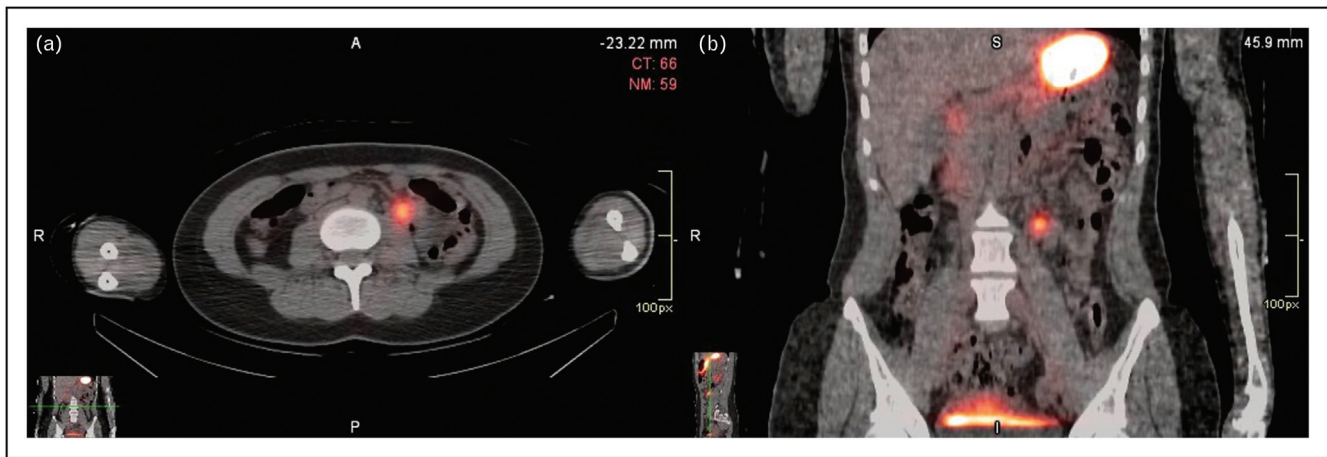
Tc-99m scintigraphy: Fused (a) axial image showing uptake in left lower quadrant, and (b) coronal image showing uptake in stomach and left lower quadrant. Uptake corresponds to the bleeding point seen on CT.
